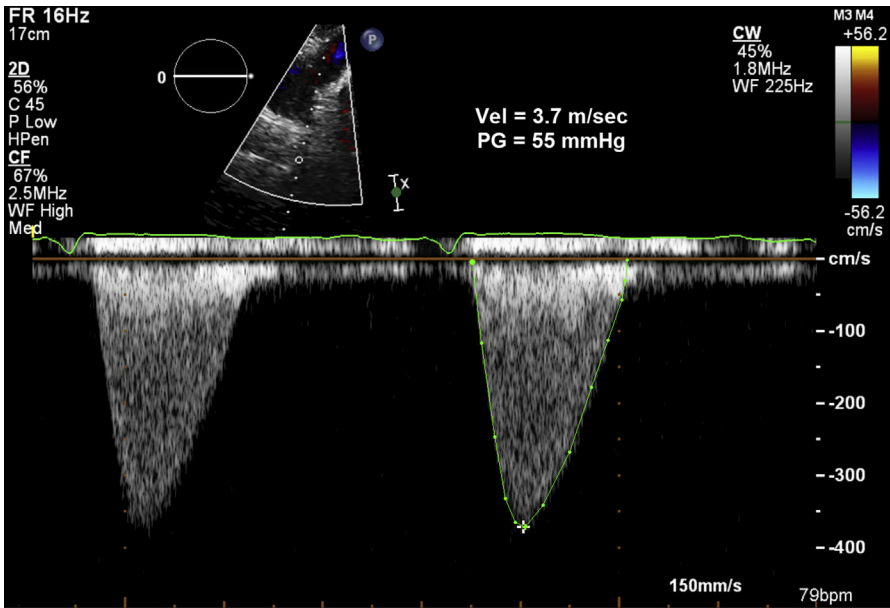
From the suprasternal view, in the same patient, use of guided Continuous Doppler demonstrates a high-velocity envelope reflective of moderately severe arch obstruction. Advanced imaging is required to further evaluate the arch anatomy.
